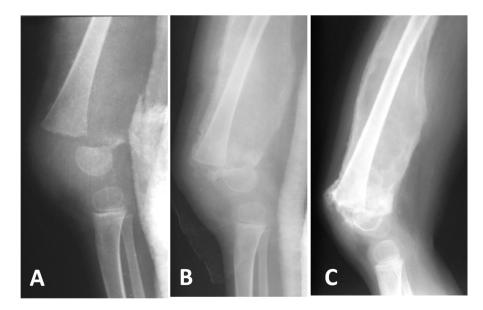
Radiographs of right thigh showing (A) lower femoral epiphyseal slip. Subperiosteal hematoma was not visible initially, (B) subperiosteal hematoma (in healing stage) after treatment was initiated, (C) final radiographs after completion of treatment.
